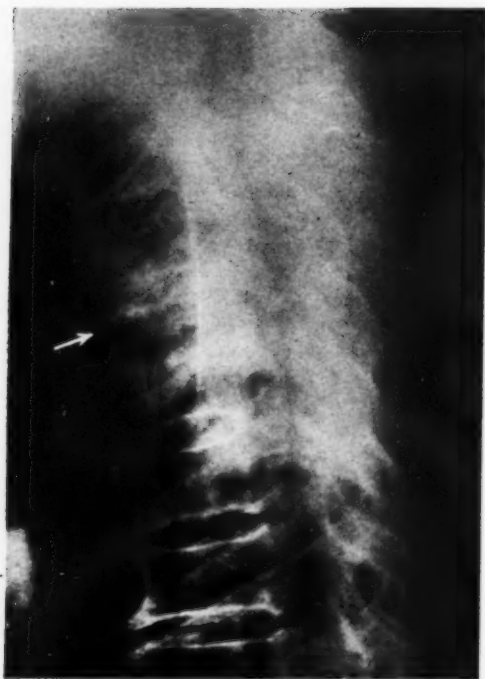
Lateral roentgenogram of the thoracic spine (Jan. 12, 1945) showing the partial collapse of the fifth thoracic vertebra with narrowing of the interspaces above and below (arrow).
